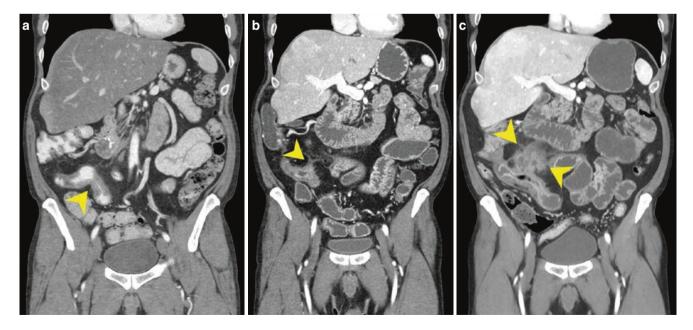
Serial CT enterography coronal images for a patient with Crohn's disease with progression from (a) structuring disease to (b) early penetrating disease and to (c) complicated disease with localized perforation with mesenteric abscess
